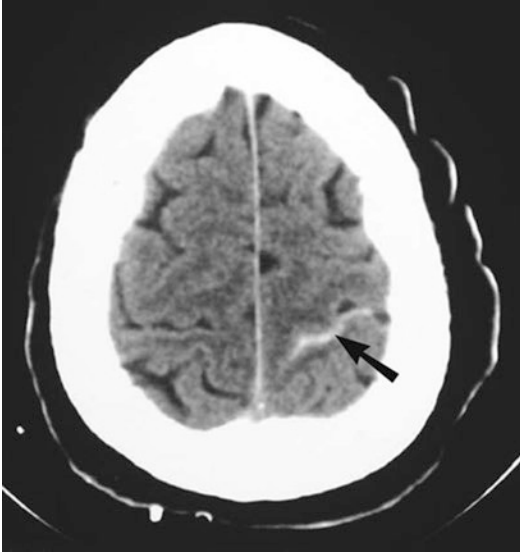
Brain CT scan of a 48 old year-old male following motor vehicle collision. It shows the hyperdense clot taking the place of CSF in the SULCUS (black arrow). You can also see normal sulci that appear dark. The straight white line in the middle is the falx cerebri and the blood in the sulcus is the white density inclined lazily at 45° to the falx cerebri (black arrow)
